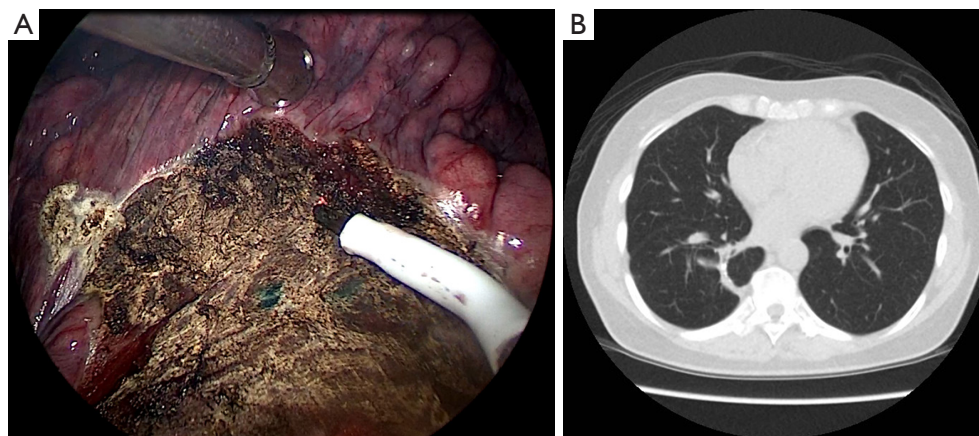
Surgical view and follow-up CT images. (A) Thoracoscopic view during dissection of the parenchyma. No blue marks were left in the remnant parenchyma; (B) follow-up CT images 2 years after the operation showed well-healing of pulmonary parenchyma with no recurrence.
